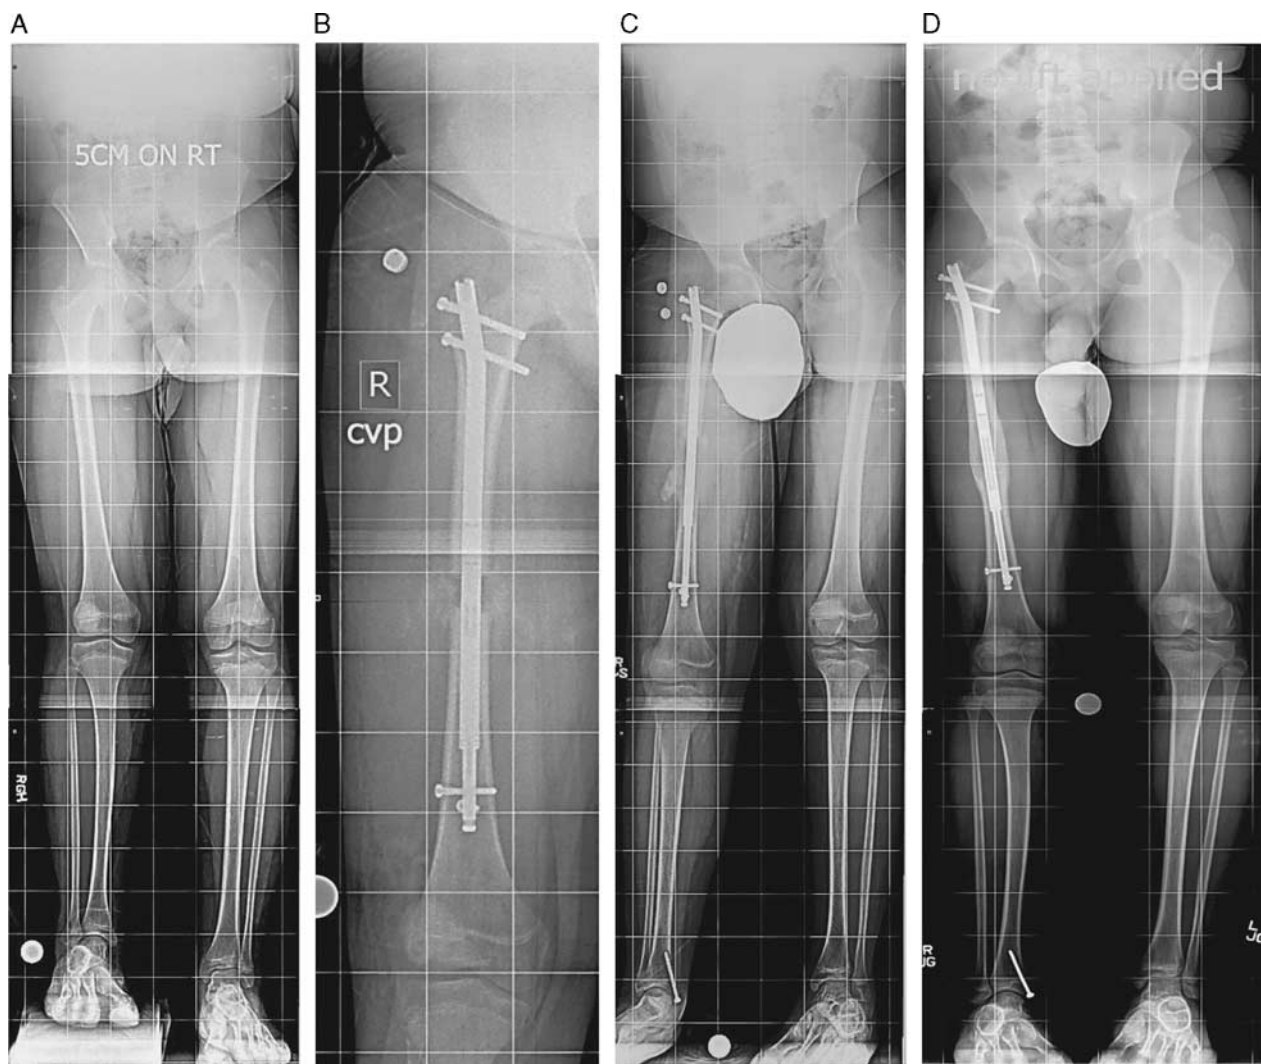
A-D, Eleven-year-old boy with right-sided congenital femoral deficiency and fibular hemimelia. A, Preoperative limb length discrepancy of 5.5 cm. B, Early radiograph depicting 1.8 cm lengthening with the PRECICE nail inserted in the right femur through the greater trochanter. Notice the natural bone graft at the osteotomy site supplied from the reamed medullary canal after venting. C, Lengthening completed 2 months after surgery. D, After regenerate healing and complete consolidation. The length achieved was 5.5 cm. Additional lengthening procedure for the right tibia will be performed in the future to achieve equal limb lengths. Reprinted with permission from Sinai Hospital of Baltimore. Copyright 2015, Rubin Institute for Advanced Orthopedics, Sinai Hospital of Baltimore, Baltimore, MD. All permission requests for this image should be made to the copyright holder.
